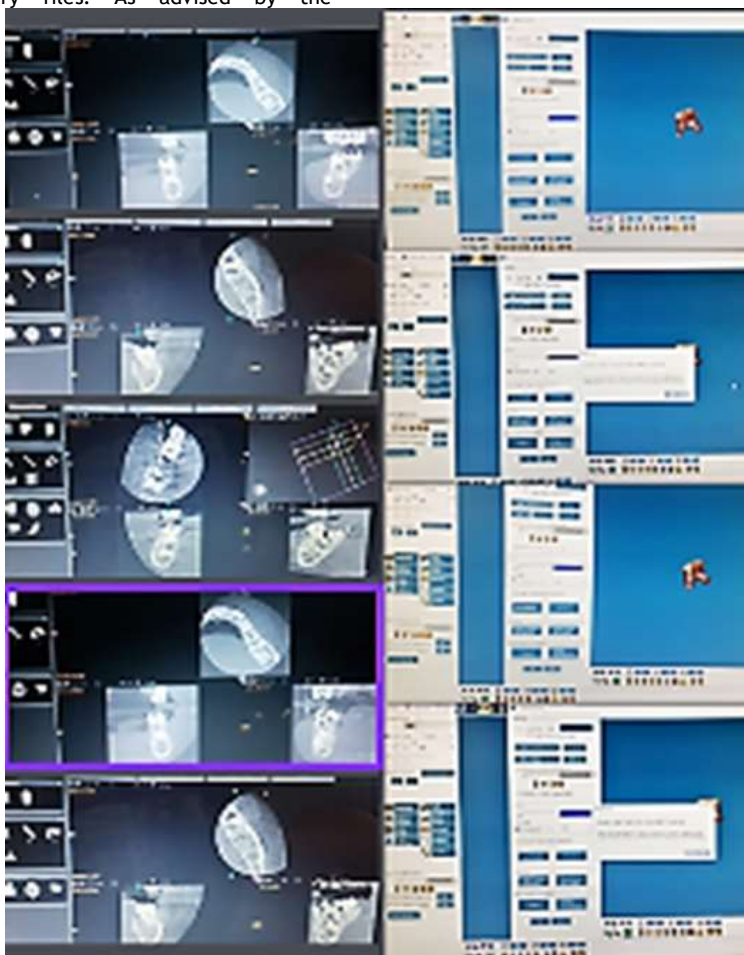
Pre-instrumentation CBCT, Post-instrumentation CBCT, Post-obturation CBCT
